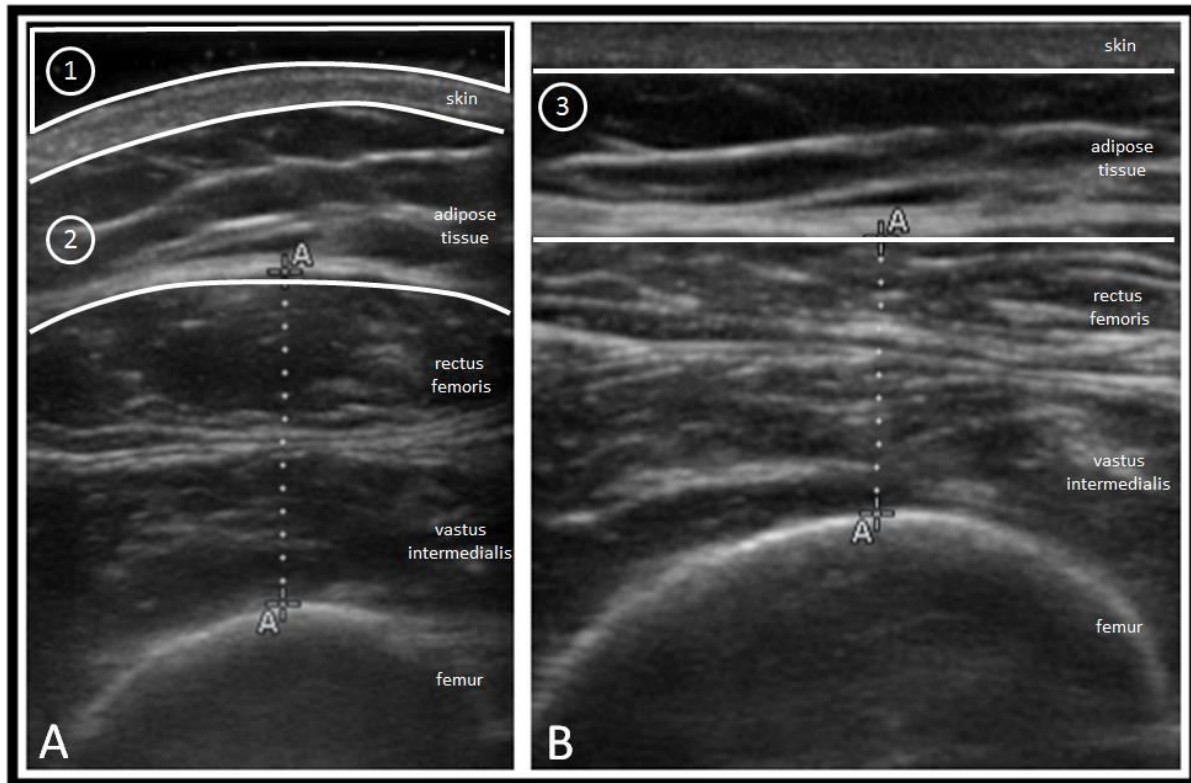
Comparison between minimal (A) and maximal compression (B) protocols within a single participant. 1 – Region highlighting ample acoustic coupling gel to ensure no contact occurs between skin and ultrasound probe. 2 – Highlighting convex nature of the skin and muscle belly, required for minimal compression. 3 – Skin and muscle belly loose convex shape during maximal compression.
